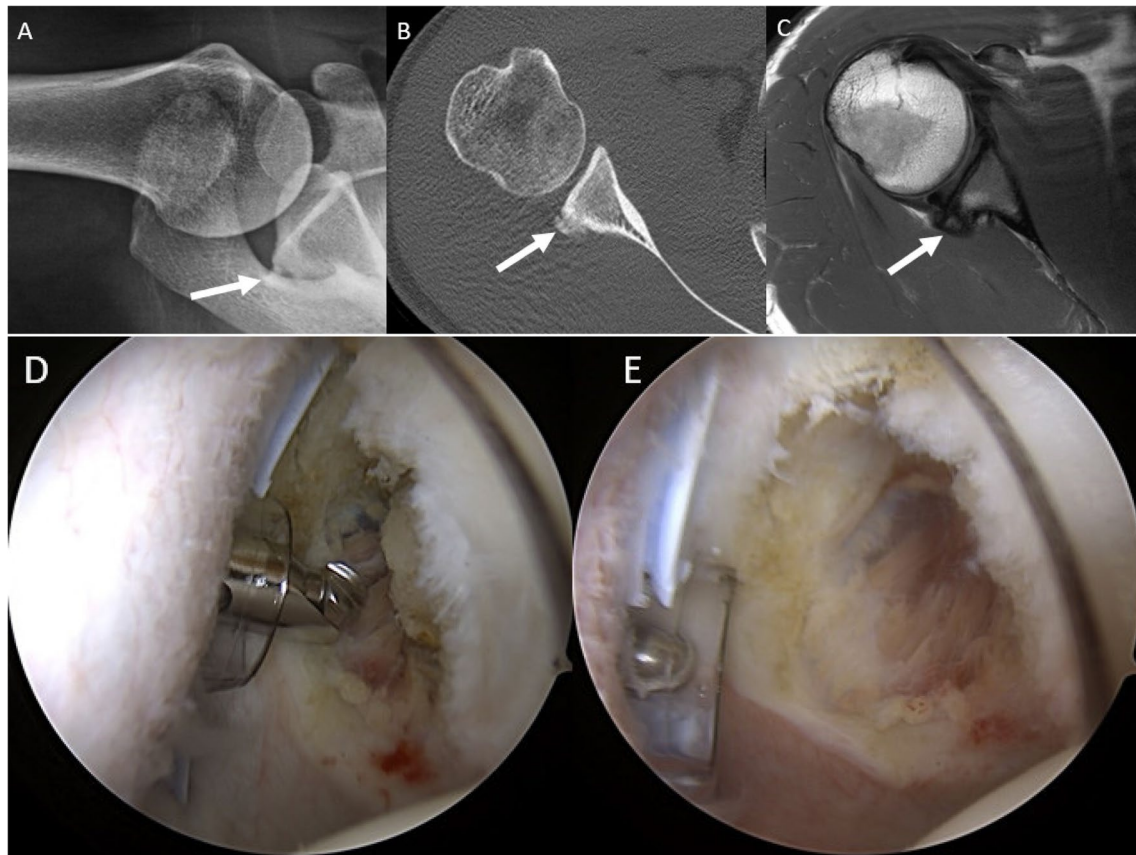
Axillary view radiograph (A), axial CT (B), and axial PD MR images (C) demonstrate a small curvilinear focus of ossification along the posterior glenoid consistent with a Bennett lesion (arrow).
